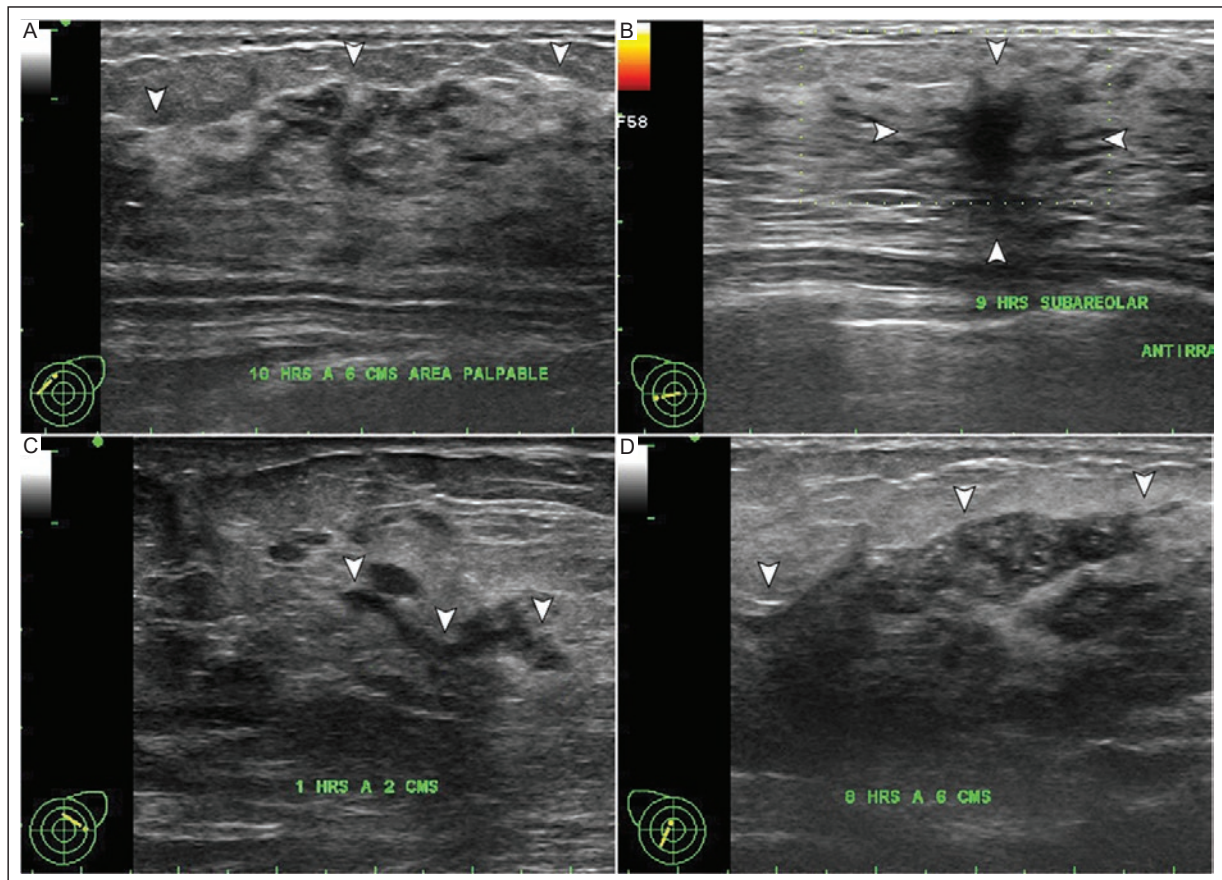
US in grayscale and power Doppler showing the distribution of breast NM A: regional (arrowheads). B: focal (arrowheads). C: linear (arrowheads). D: segmental (arrowheads).
